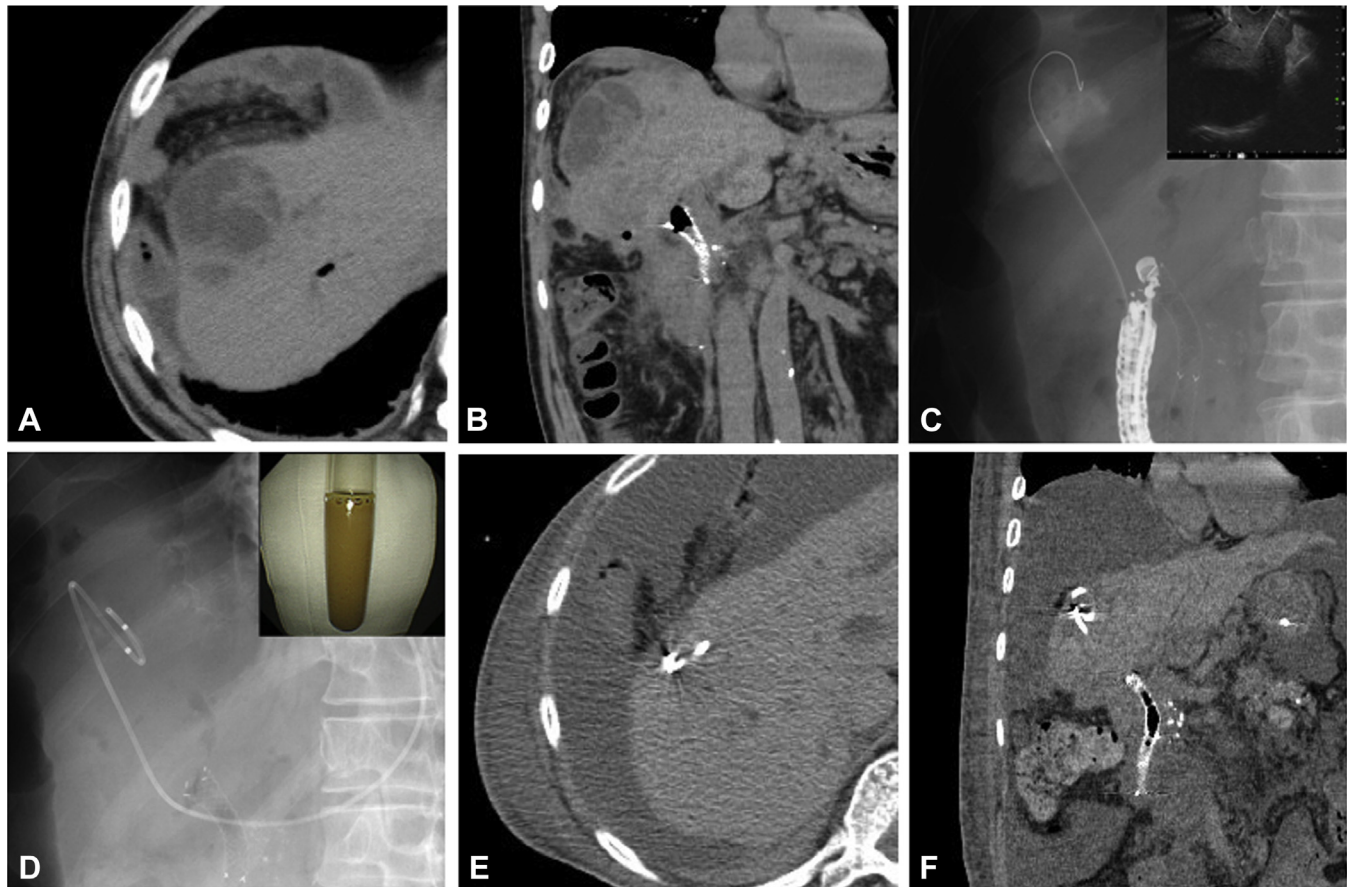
A, CT view showing the abscess in the right side of the liver and Chilaiditi syndrome. B, CT view showing the internal metallic stent placed into the common bile duct. C, The abscess was punctured with a 19-gauge EUS-FNA needle from the duodenum. D, Placement of a 5F nasocystic tube in the abscess and aspiration of pus from the abscess. E, F, CT view after EUS-hepatic abscess drainage showing complete disappearance of the abscess.
